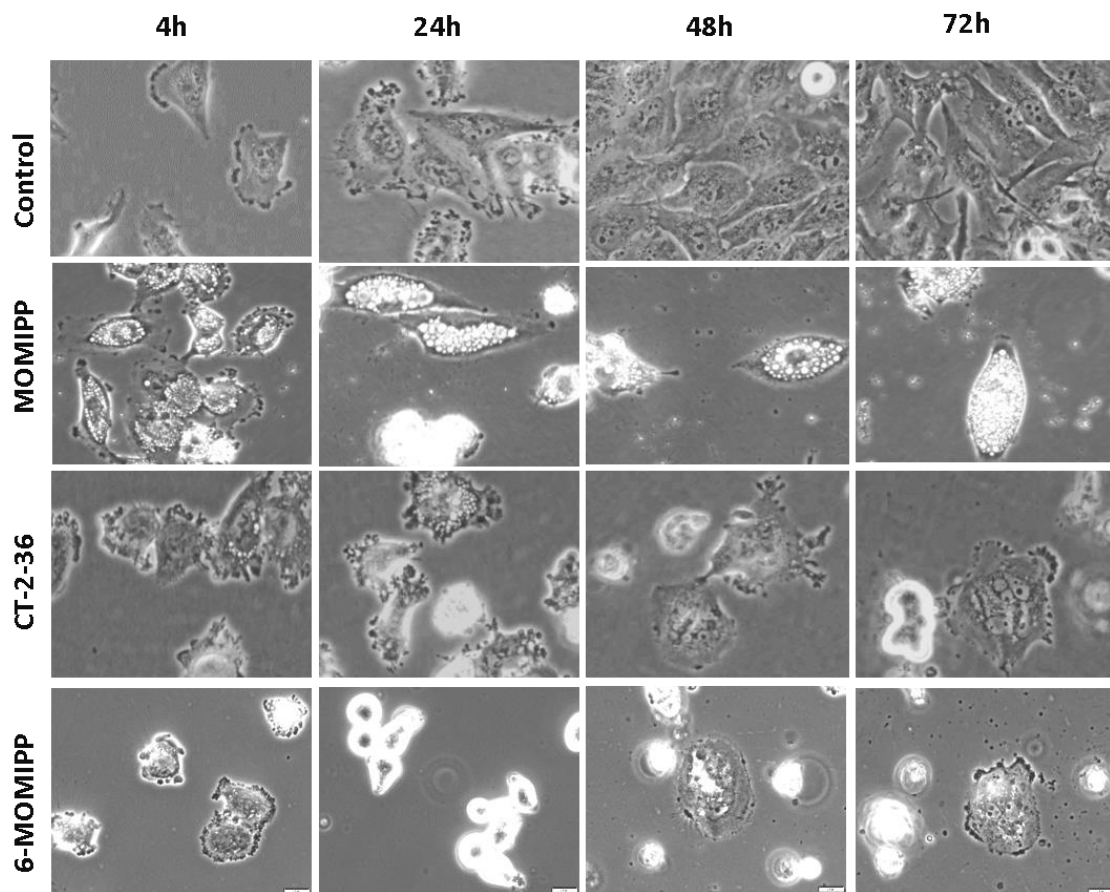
Comparison of the effects of MOMIPP, CT-2-36, and 6-MOMIPP in U251 cells. 100,000 U251 cells were seeded in 35mm dishes and treated with DMSO, 10 μ M MOMIPP, 0.6 μ M CT-2-36 or 1 μ M 6-MOMIPP. Phase-contrast images were taken after 4 h, 24 h, 48 h, or 72 h.
